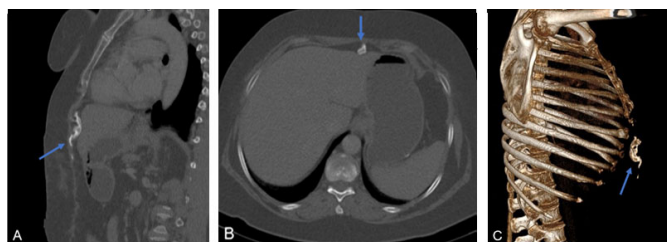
(A) CT scan thoracoabdominal, bone window sagittal. (B) CT scan thoracoabdominal, bone window axial. (C) 3D reconstruction, vertical linear calcified lesion in the anterior abdominal wall in front of the small xiphoid region (blue arrow): heterotopic ossification.
